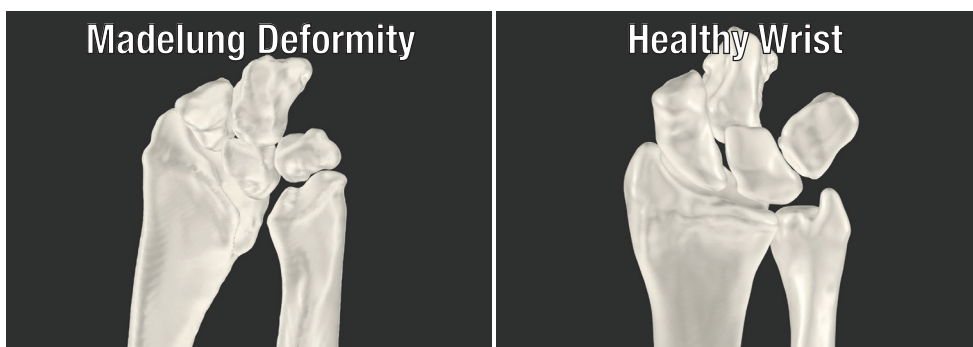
Three-dimensional reconstruction of the wrist after segmentation of CT scan.
